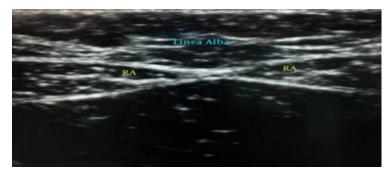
Ultrasonographic Image showing Linea Alba with two Rectus Abdominis (RA) muscles
